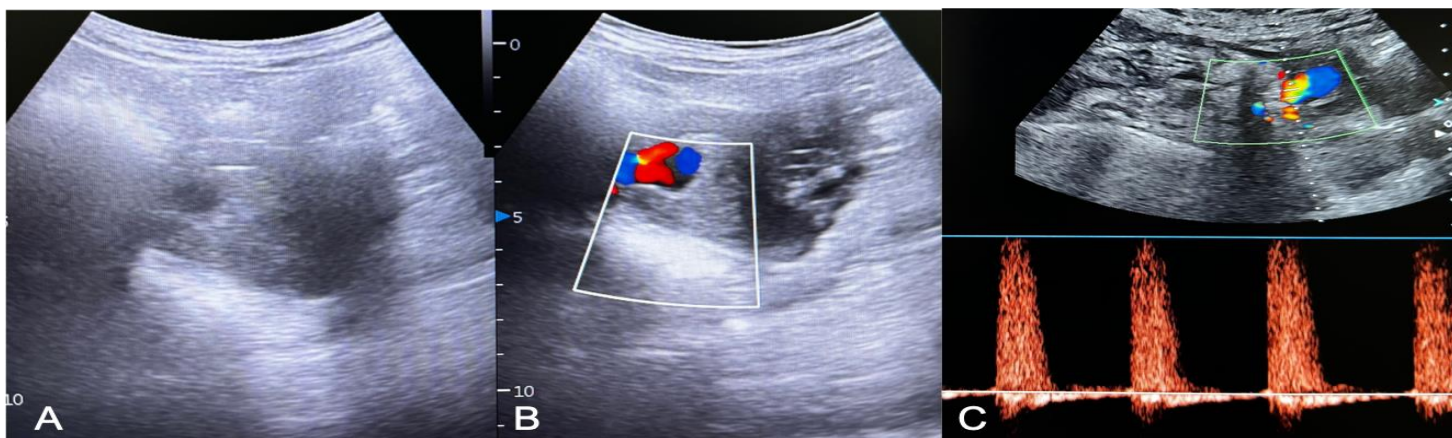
(A-C): Transverse grey scale ultrasound image showing a round hypoechoic lesion in uterus (white asterisk) (A). Colour Doppler image of the same lesion showing “Yin-Yang” pattern (B). Spectral Doppler showing to and fro pattern (C)
